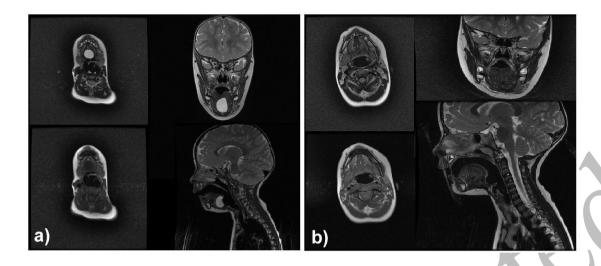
a) Magnetic resonance imaging (MRI) visualisation of thyroglossal duct cyst; b) MRI of surgical area after one year of follow-up
